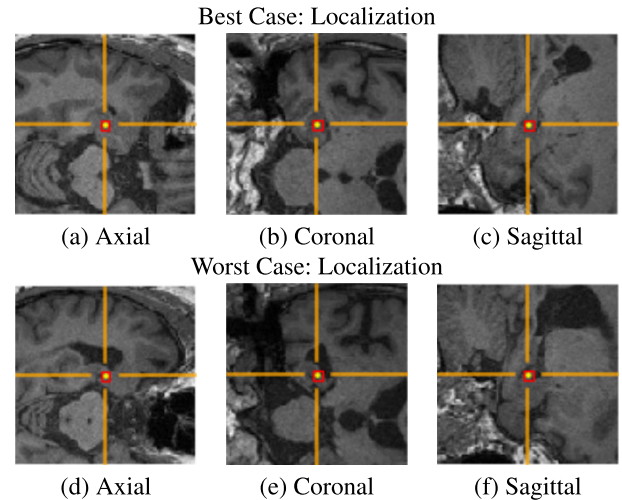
The representative automatic localized position of right hippocampus is shown in (a, b, c) and (d, e, f) for best case and worst case (respectively) of the axial, coronal and sagittal views by the two-stage ensemble Hough-CNN of the test MRI scans. Two-stage ensemble Hough-CNN localized position is used to extract patches for DVE-CNN. The DVE-CNN estimated slice-wise volumetric features are used to classify the AD and NC classes.
